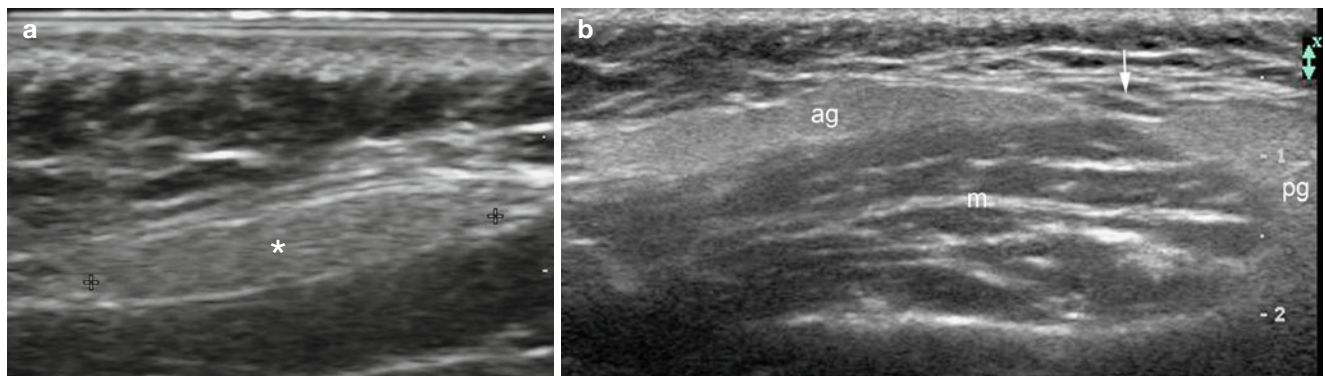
(a, b) Accessory salivary glands. (a) Ultrasound (transverse view) at the right cheek shows hyperechoic oval-shaped and well-defined structure (*, between markers) adjacent to the surface of the masseter muscle. (b) Ultrasound in another case (transverse and wider
